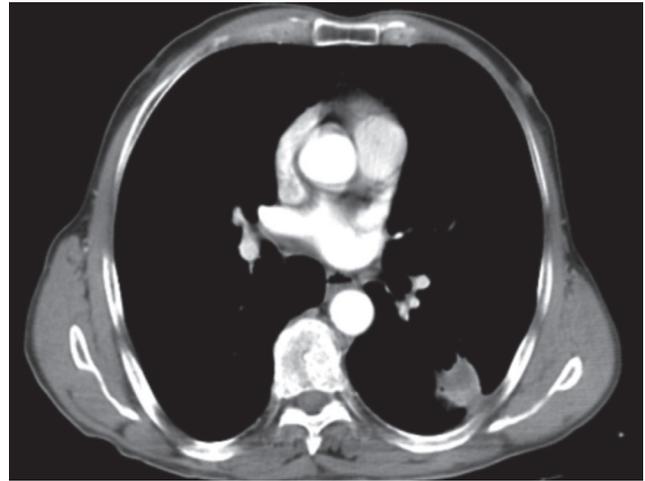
Thoracic computed tomography
